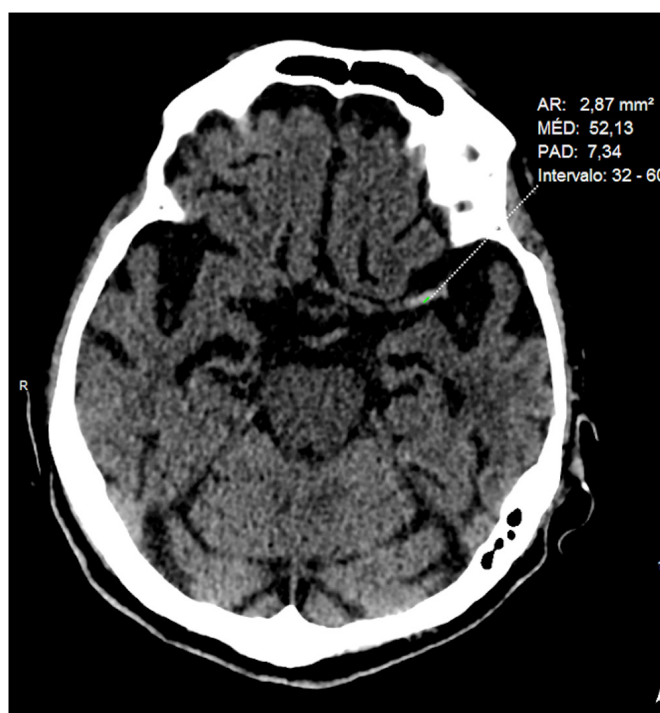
Non-contrast CT scan.
